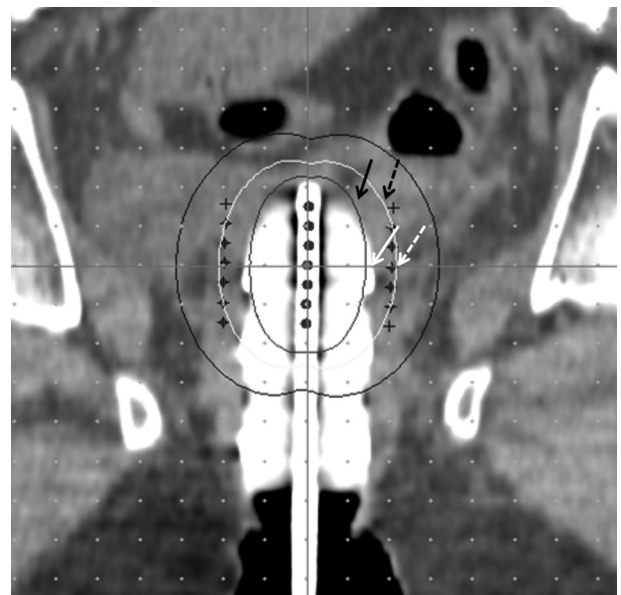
Coronal section of planning CT cut showing CVS applicator with loading and 100% isodose line (white) at 5 mm from CVS surface. Dose was estimated at cylinder surface and at 5 mm depth at vaginal apex (black solid and dashed arrow) and at 2 cm from vaginal apex (solid white and dashed white arrow). CVS = central vaginal source.
